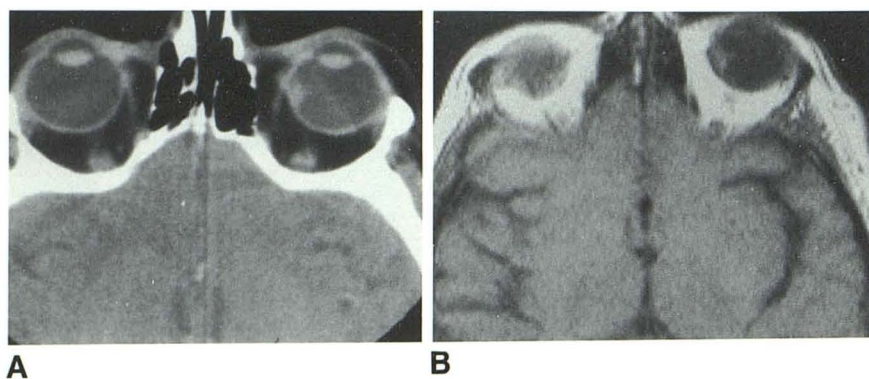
Choroidal melanoma. A, Contrast-enhanced CT scan shows 4 mm hyperdense lesion in medial quadrant of left globe that could represent either hemorrhage or tumor. Lesion had same appearance on unenhanced CT. B, SE 500/30. The 4 mm melanoma is well imaged in medial quadrant of left globe.
